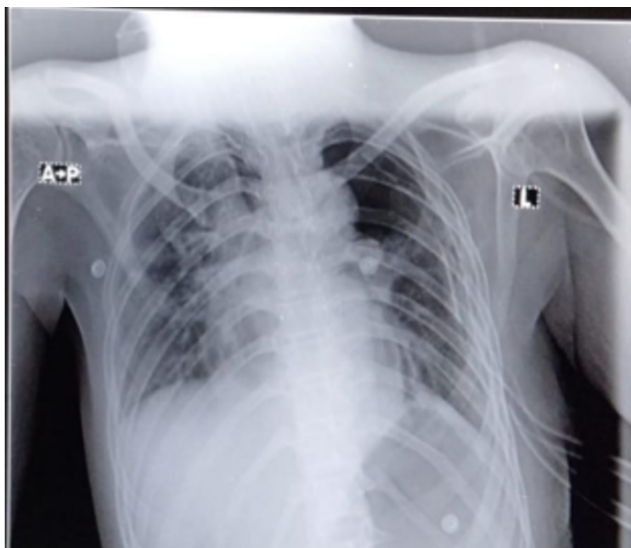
Post operative chest x-ray of the patient
